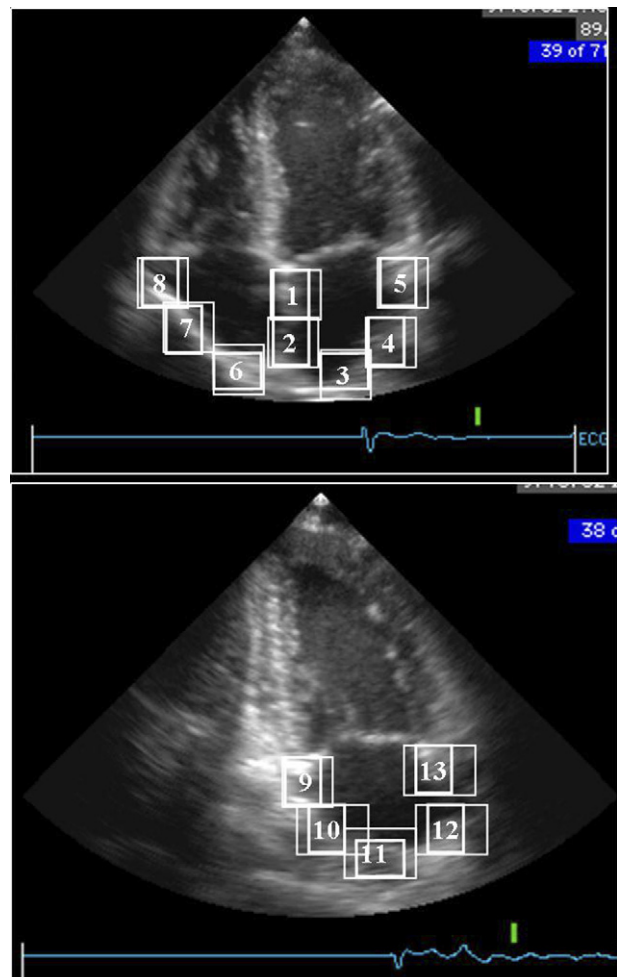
Atrial segments from the apical four- and two-chamber views. Apical four-chamber view (1, septal annular segment; 2, septal mid-segment; 3, superior segment; 4, lateral mid-segment; 5, lateral annular segment; 6, lateral annular RA segment; 7, lateral mid-RA segment; 8, superior RA segment). Apical two-chamber view (9, posterior annular segment; 10, posterior mid-segment; 11, superior segment; 12, anterior mid-segment; 13, anterior annular segment).
